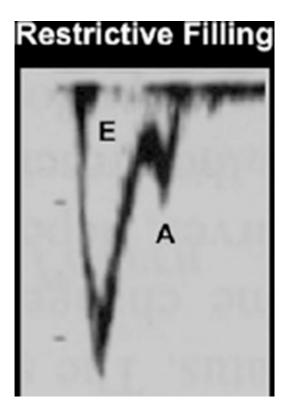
Severe diastolic dysfunction. Transesophageal echocardiography image of a restrictive pattern
